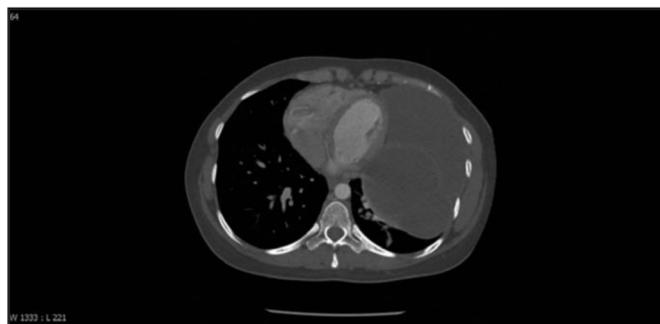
Computed tomography scan of the thorax with axial view demonstrating a large multicystic mass taking up the entire left hemithorax.
